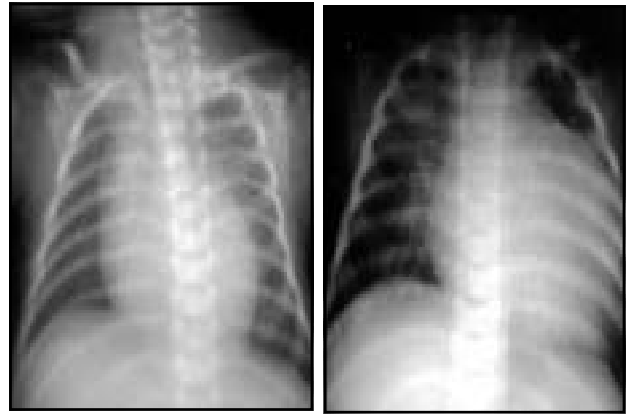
Chest radiographs showing a) normal cardiac size at 22nd day and b) showing cardiomegaly in 5th month.
